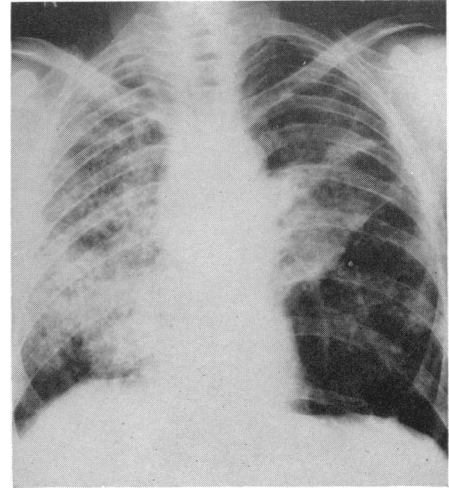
Case 3. Radiograph of chest, May, 1949.
